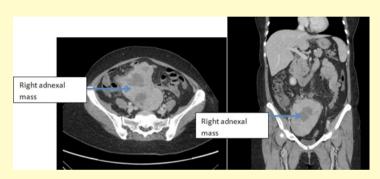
CT scan showing the right adnexal mass.
